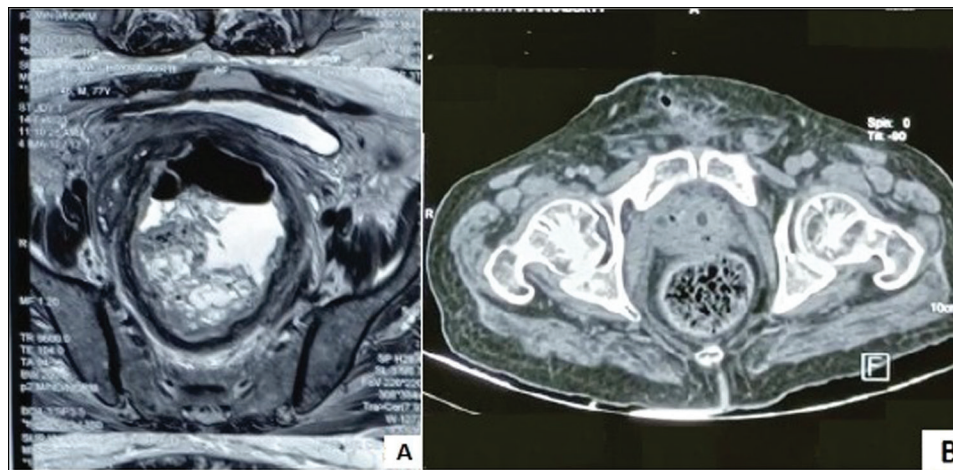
MRI pelvis and CECT pelvis—large SOL with heterogenous signal in rectovesical space of size 10.4 × 10.9 × 11 cm
